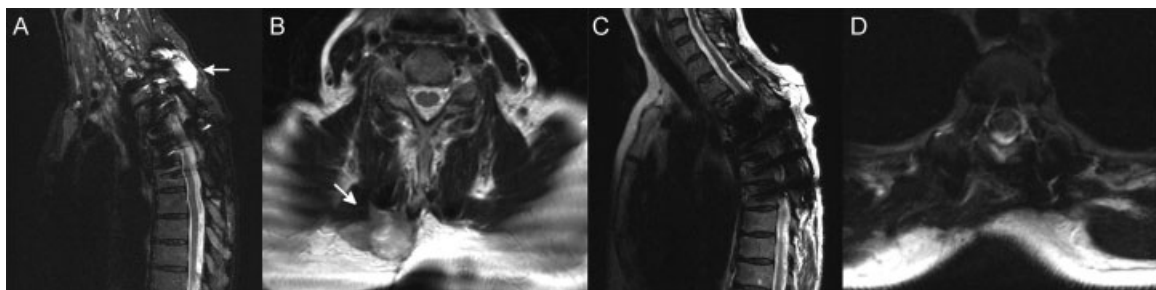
Magnetic resonance images (MRI) showing the postlaminectomy desmoid tumor (DT) and results after surgical excision. (A) Preoperative sagittal STIR MRI showing the DT (arrow). (B) Preoperative axial T2-weighted MRI of the same tumor (arrow). (C) Postoperative sagittal T2-weighted MRI demonstrating absence of tumor. (D) Postoperative axial T2-weighted MRI demonstrating absence of tumor.
